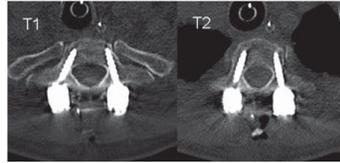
Postoperative CT axial spine showing satisfactory placement of T1-2 pedicle screw.
